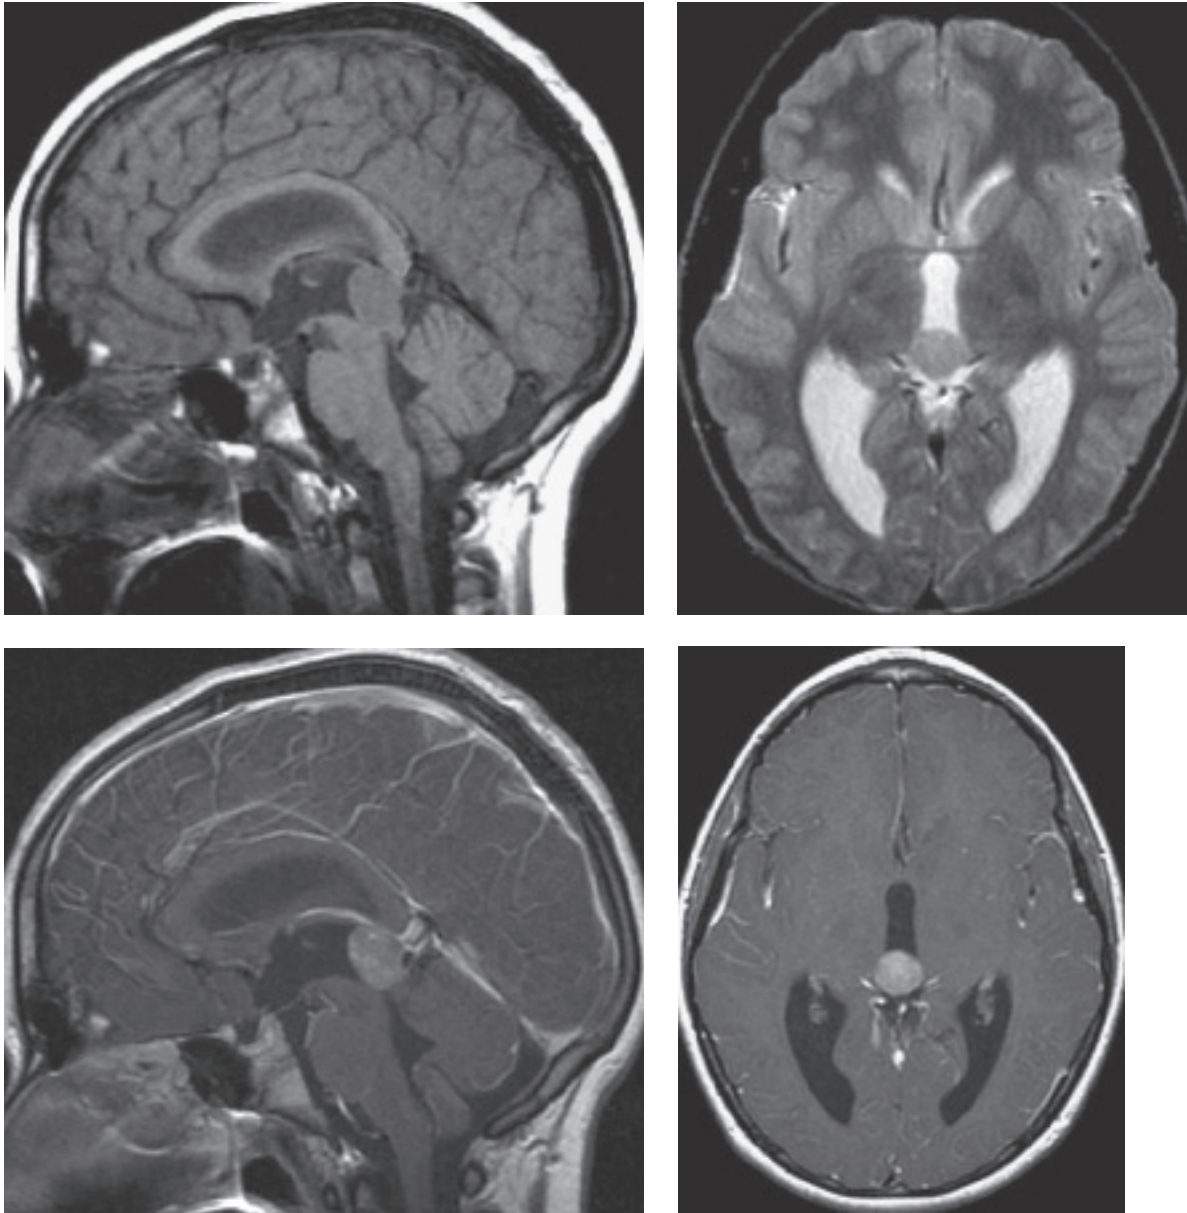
(A) Sagittal T1, (B) axial T2 fast spin echo, and (C) sagittal and (D) axial T1 postgadolinium images demonstrate a pineal region mass that is intermediate in signal intensity on both T1- and T2-weighted sequences with homogeneous enhancement. There is mass effect on the tectal plate with obstructive hydrocephalus at the level of the cerebral aqueduct.
